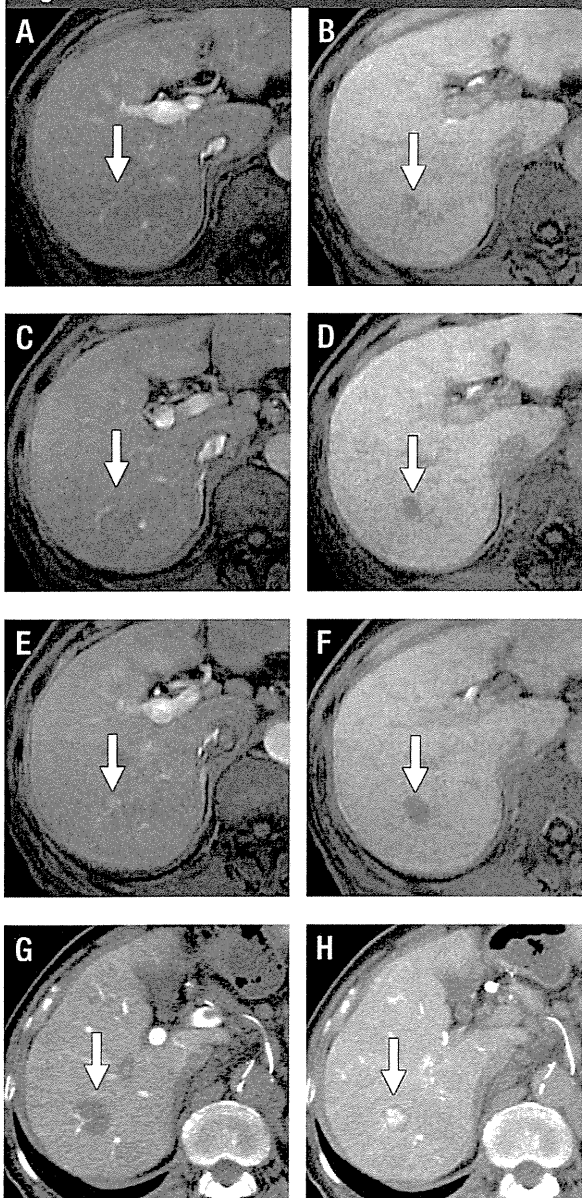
Growing hypovascular hepatic nodule (arrows) and subsequent hypervascularization in an 86-year-old man with hepatitis C and Child-Pugh class B cirrhosis. A-F, Axial gadoxetic acid-enhanced T1-weighted fat-suppressed three-dimensional gradient-recalled echo images obtained during (A, C, and E) arterial phase and (B, D, F) hepatobiliary phase obtained at (A, B) baseline, (C, D) day 94, and (E, F) day 176. At (A) baseline and (C) day 94, hepatic nodule in right posterior section showed neither arterial-phase enhancement nor portal-venous phase washout. Hepatobiliary phase images showed that maximum diameter increased from 8 mm at (B, baseline) to 12 mm at (D, day 94), and TVDT was calculated as 170 days. E, Arterial-phase image at day 176 shows partial enhancement of nodule. G, At day 194, CT arterial portographic image shows a well-defined, round perfusion defect and (H, CT hepatic arteriographic image shows marked enhancement corresponding to nodule. Nodule was diagnosed as HCC on the basis of image views and tumor markers.
